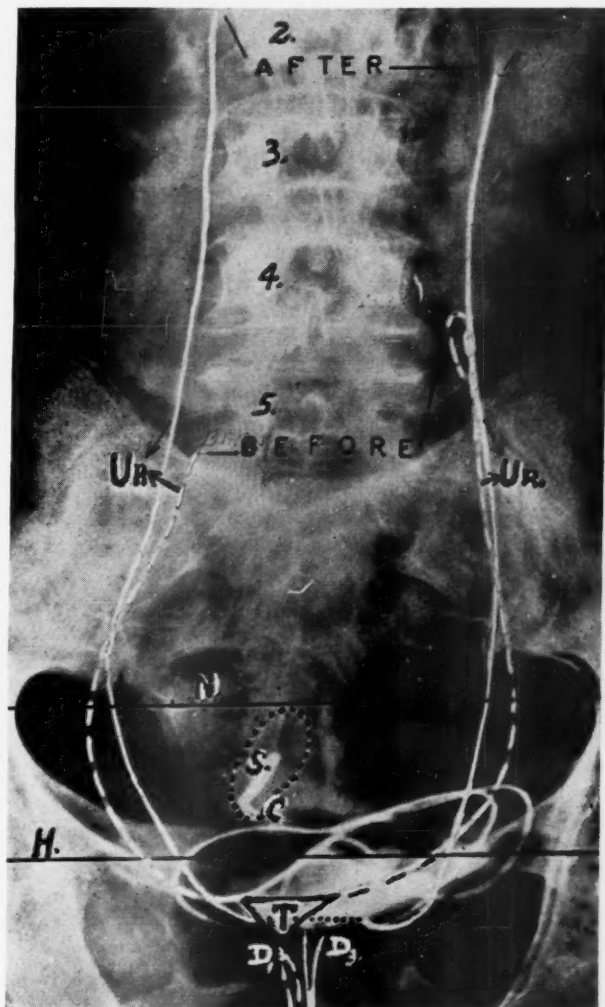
Shows one roentgenogram of the bladder, the ureters, and the replaced prolapsed uterus and cervix, superimposed on a second roentgenogram of the bladder, and ureters which was made after operation for prolapse (the cervix and uterus being removed).
